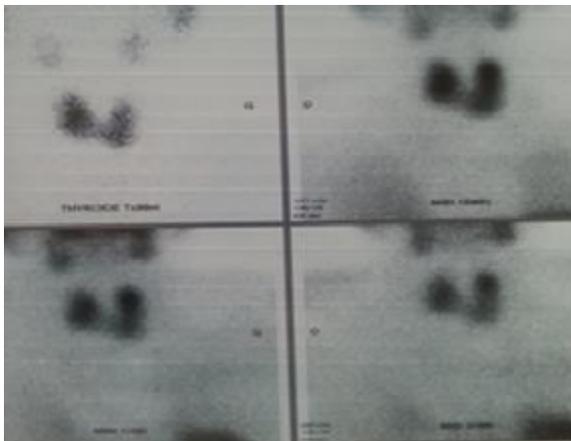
44-year-old woman with primary hyperparathyroidism, 99mTc-MIBI scintigraphy revealed persistent superior left polar delayed fixation in relation to left superior parathyroid adenoma.
